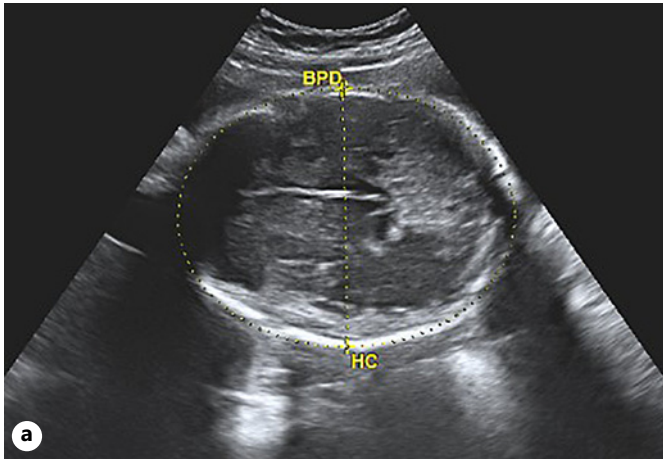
a, b Antenatal ultrasound: antenatal ultrasound on the day of delivery showing crescent hyperechoic collection suggestive of SDH 8×1.2 cm (dotted lines 1 and 2).
